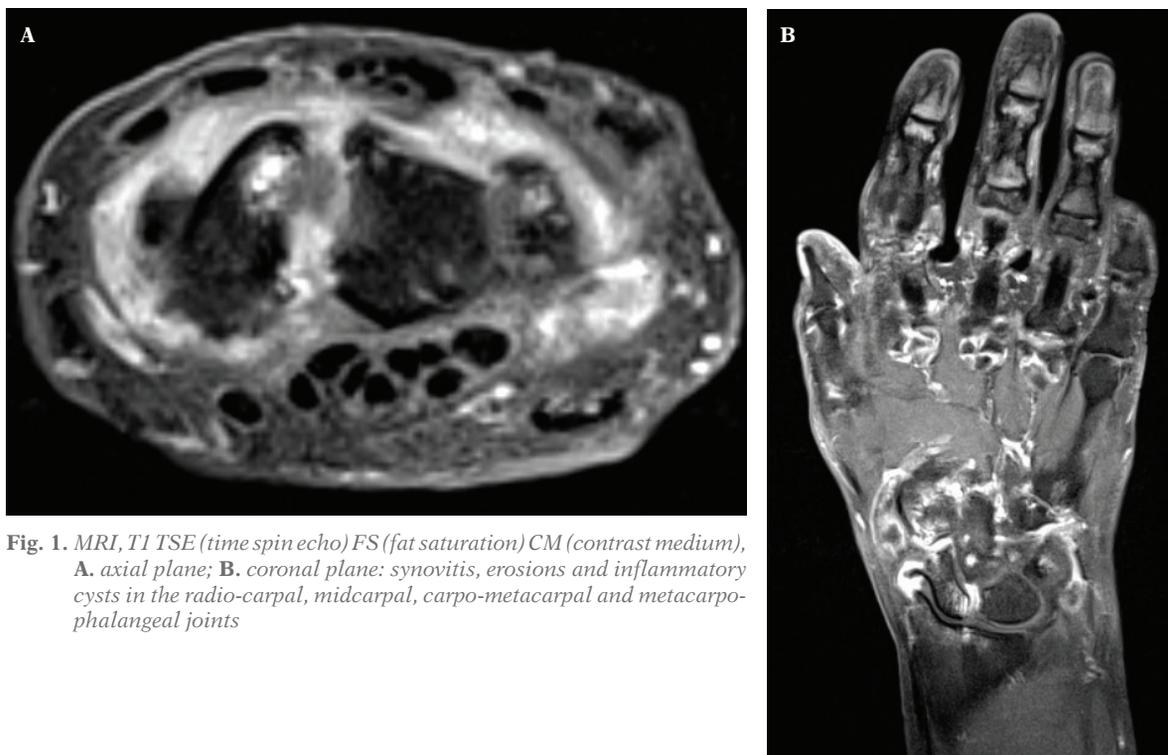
MRI, T1 TSE (time spin echo) FS (fat saturation) CM (contrast medium), A. axial plane; B. coronal plane: synovitis, erosions and inflammatory cysts in the radio-carpal, midcarpal, carpo-metacarpal and metacarpophalangeal joints
